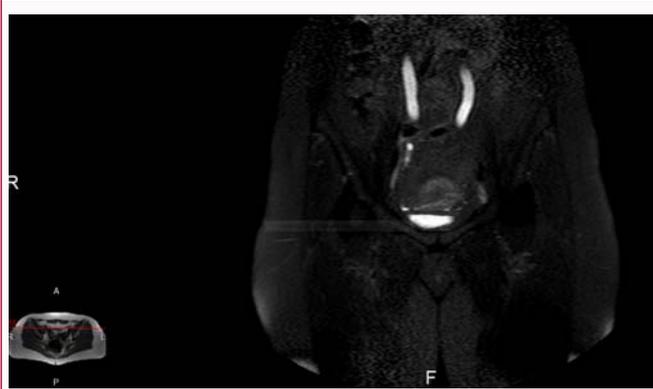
Dilated ureters in a 42-year-old patient with ureteric endometriosis, presenting with acute renal failure and hypertension- Magnetic Resonance Imaging.
